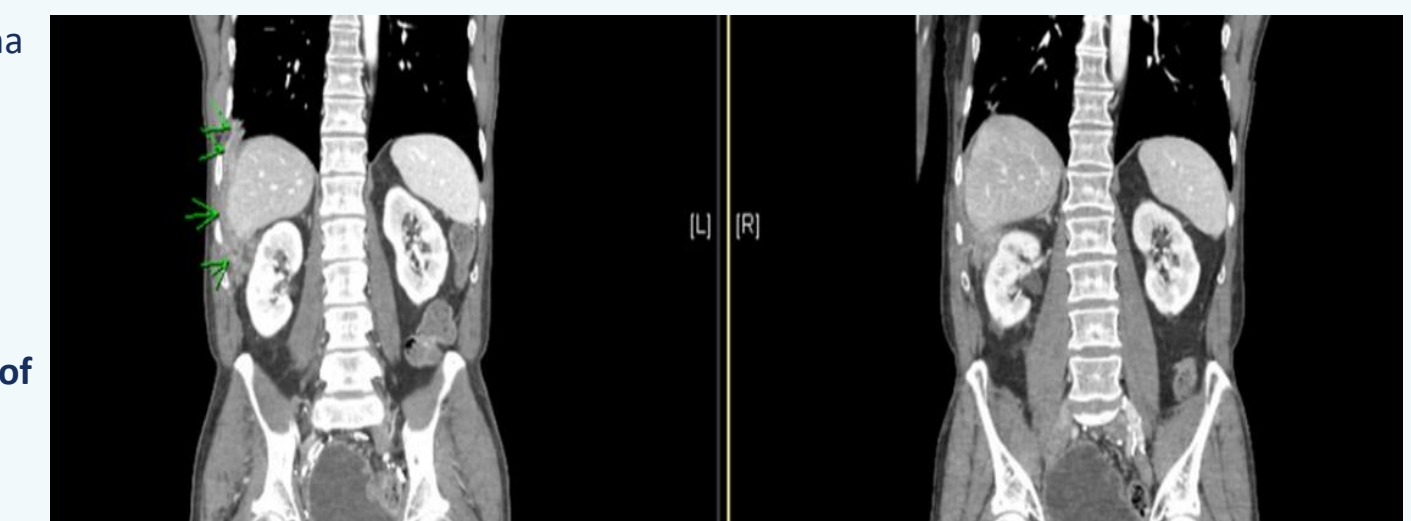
Radiographic Scan of Monotherapy Patient
